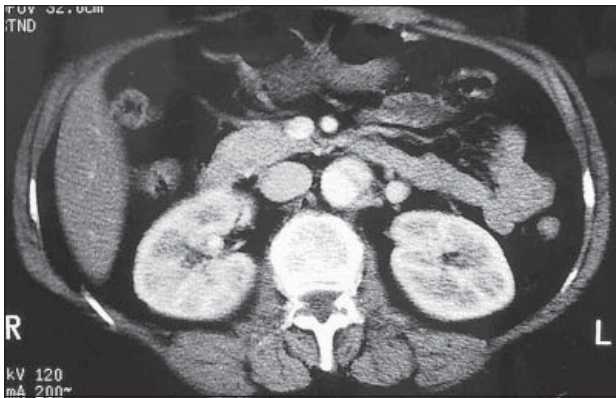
Contrast axial computed tomography of the abdomen showing abdominal aortic dissection.
